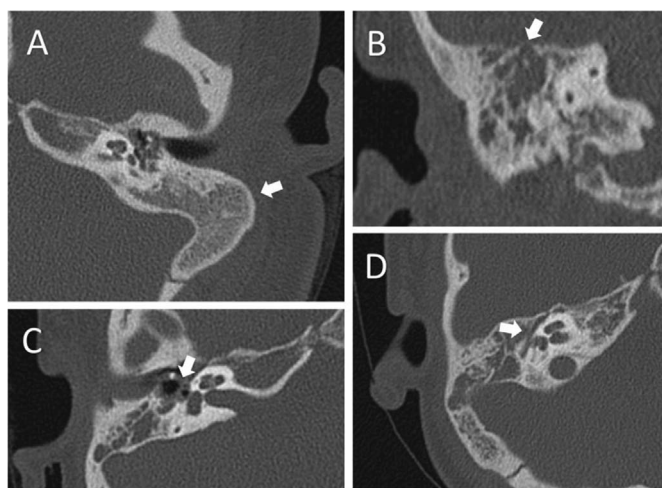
Representative Computed Tomography (CT) findings associated with cholesteatoma in Down syndrome patients. Extensive mastoid sclerosis (A). Possible tegmen erosion (B). Erosion of the incus long process and stapes (C). Possible erosion of the horizontal facial canal (D).
